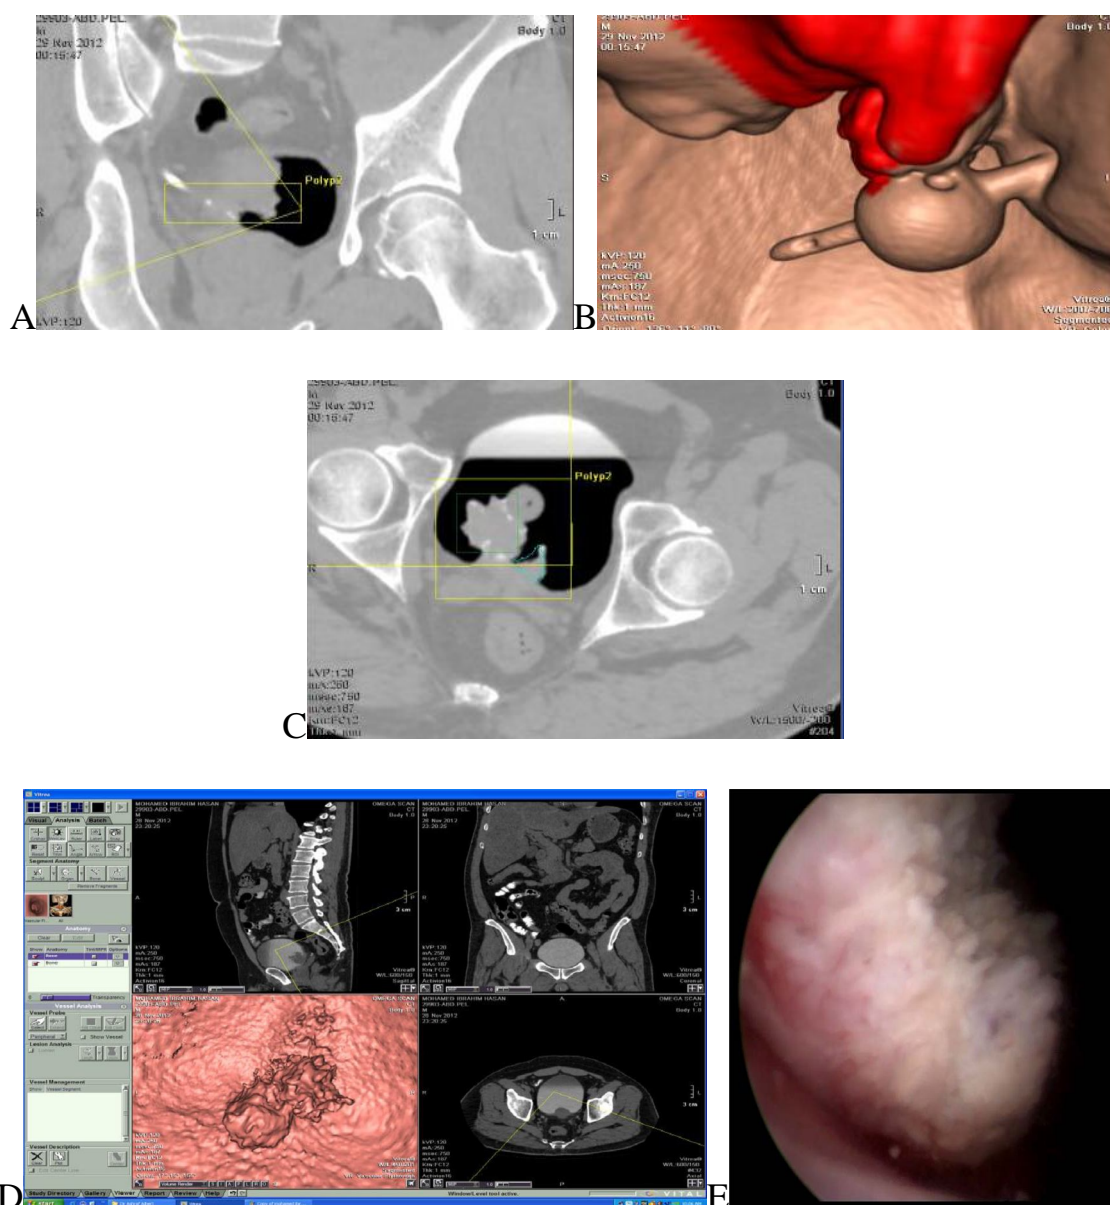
Male 47 years old patient presented with bladder mass on routine ultrasound examination. Axial, coronal and sagittal images showed single irregular shaped polypoidal mass at the trigon urinary bladder, measuring about 3 x 2 cm. CTU and Virtual images using the iodinated contrast filled then the air filled bladder techniques clearly visualized the bladder mass. E) Conventional cystoscopy revealed relative large intravesical fungating mass arising from UB trigon. Diagnosis: Transitional cell carcinoma (Grade 11).
